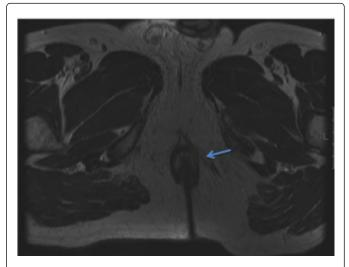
Diagnostic MRI (supine). Fiber tracts around the left pudendal terminal branches.
